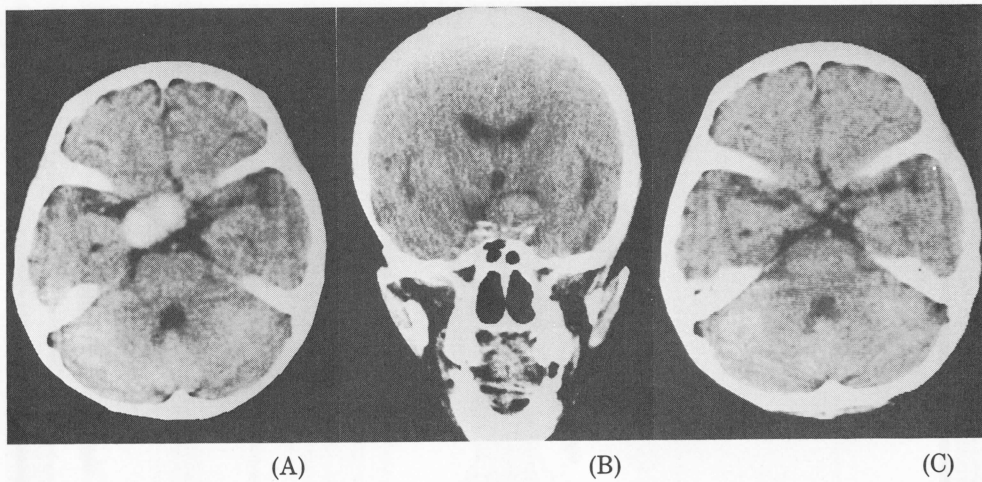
Repeat plain CT scans after ligation of the cervical ICA in Case 1. The isodense mass has changed to a hyperdense mass 2 weeks after carotid occlusion (A). A coronal CT scan 5 weeks after ligation shows that the aneurysm gradually loses its well-defined margin, and the density is decreased (B). The density becomes isodense with a slight reversal of the mass effects 6 months after surgery (C).
